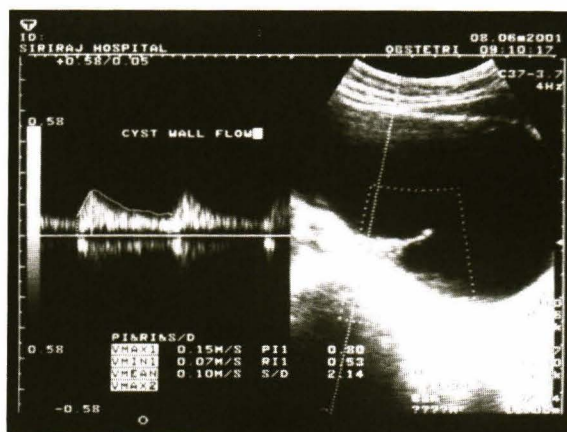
Transabdominal ultrasonography, showing Doppler study of the cystic wall artery with a resistant index of 0.53.
